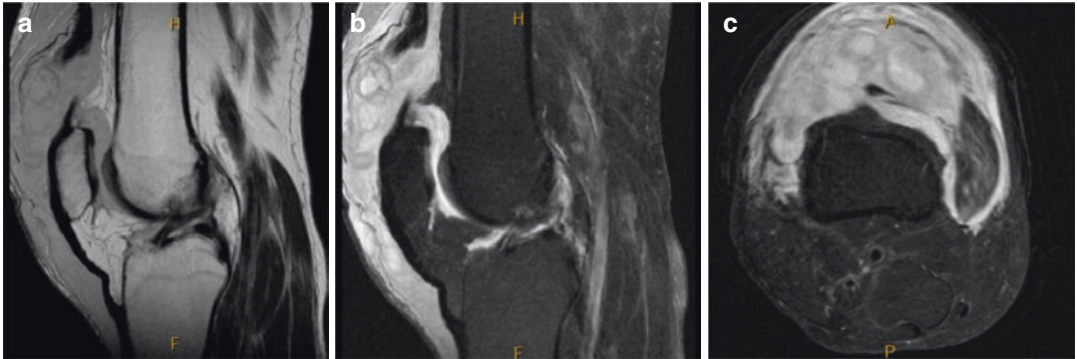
Pre-operative MRI. (a and b) Sagittal views demonstrating quadriceps tendon tear and gap formation. (c) Axial view demonstrating complete tear of quadriceps tendon
